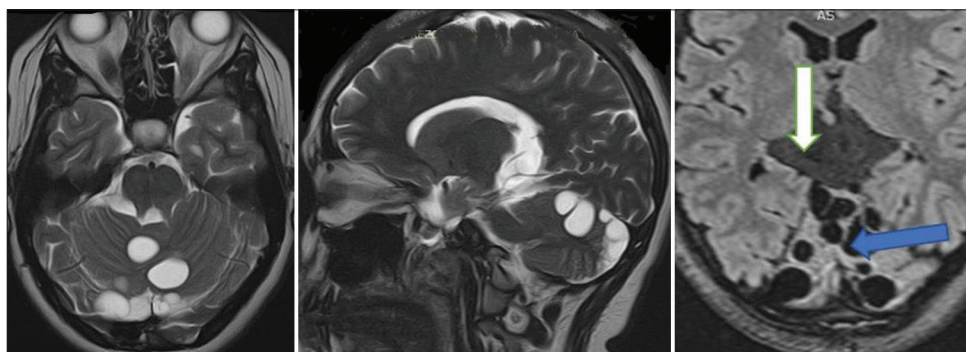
MRI at 20-month postoperative showing increased number of cysts (blue arrow) and progressive increase in pineal cyst size (white arrow).
